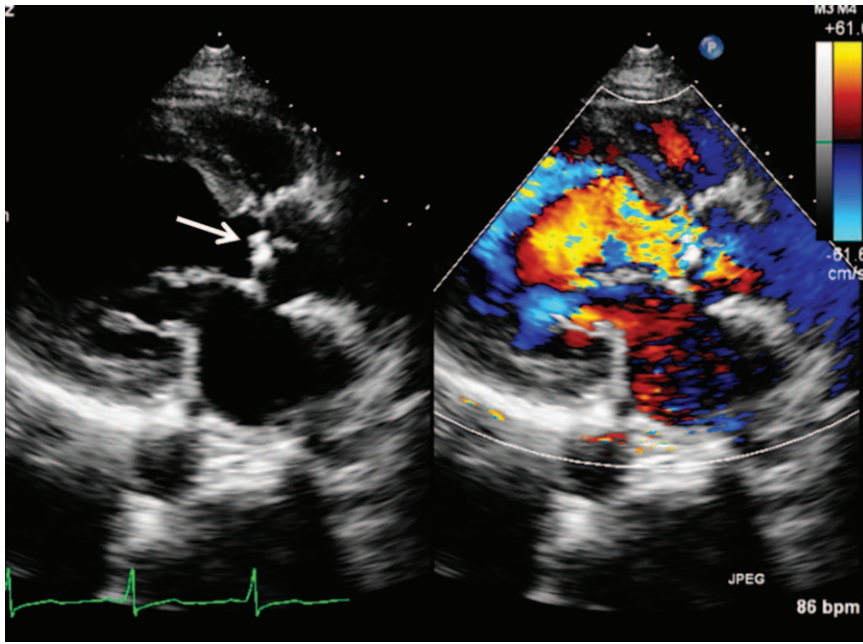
Parasternal long axis view showing vegetation on aortic valve (arrow) and severe aortic regurgitation.
